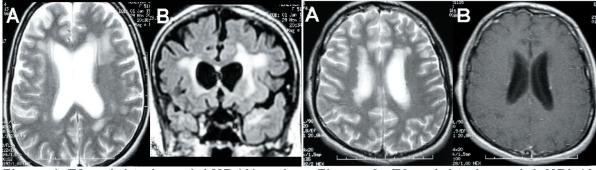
T2-weighted cranial MR (A) and FLAIR MRI (B) showed frontoparietal cortical atrophy, arachnoid cyst on the right parietal vertex and diffuse, bilateral T2-hyperintense lesions which like leukoencephalopathy.
